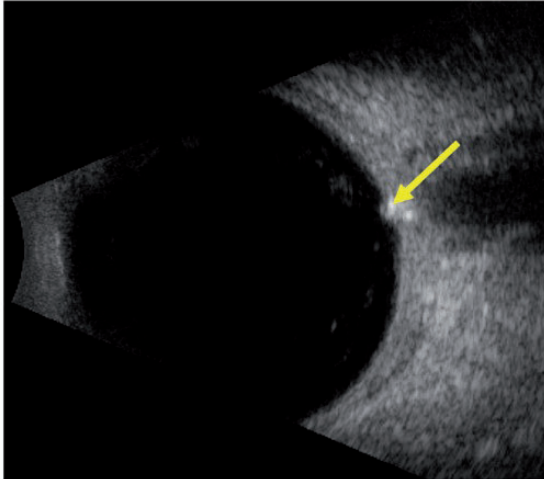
B-scan ultrasonography in a patient with OND. A hyperechogenic round structure (yellow arrow) with posterior acoustic dark shadowing in the optic nerve of the right eye is observed.
